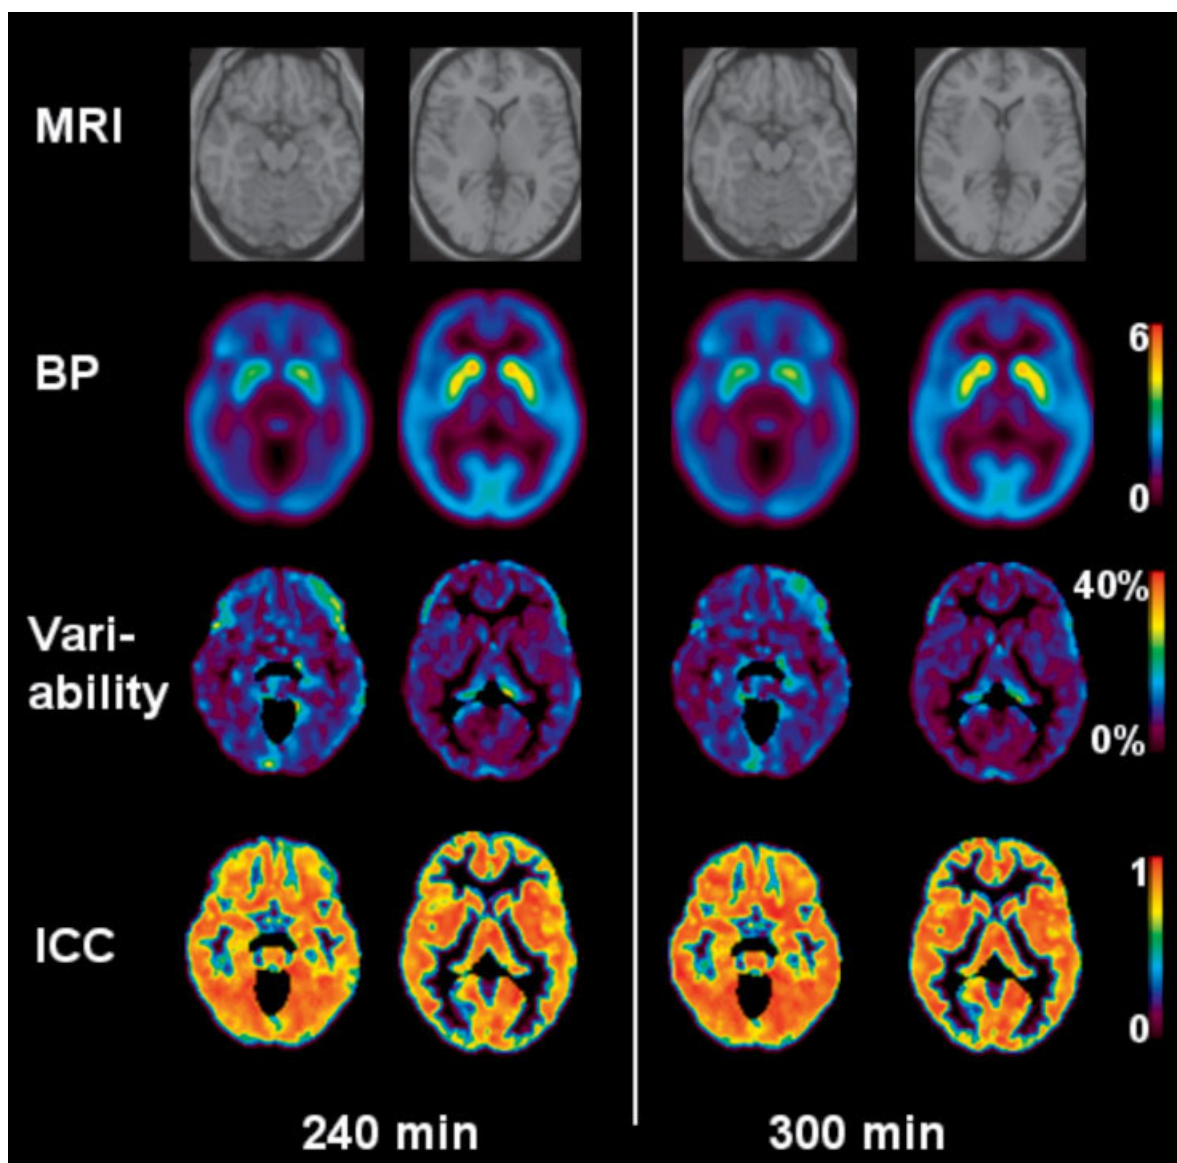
T1-weighted MRI and parametric images of BP, variability, and reliability (ICC) for an inferior (cerebellar) and superior (striatal) slice. Variability and ICC images were masked (i.e., shown in black) at BP > 0.3 and by segmented gray matter MRI image. Parametric images for BP, variability, and ICC were similar for 240- and 300-min data.
